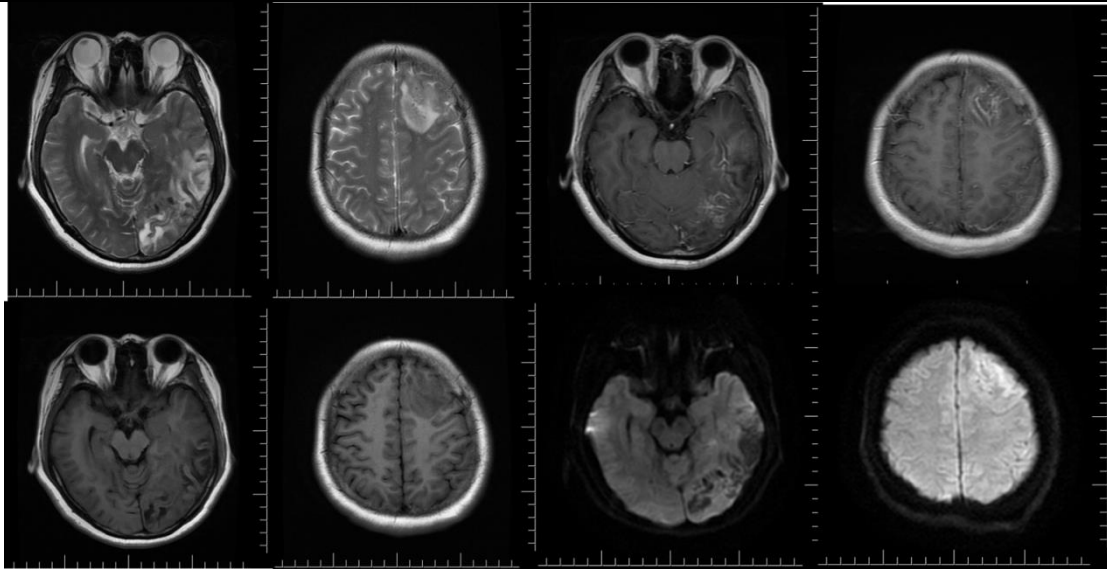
Magnetic resonance imaging (MRI) shows multiple and patchy lesion. T1-weighted and T2-weighted signal shadows are slightly longer. Restricted diffusion of patchy cortical areas can be found in diffusion-weighted imaging (DWI). Enhanced magnetic resonance imaging showed gyri like enhancement.
